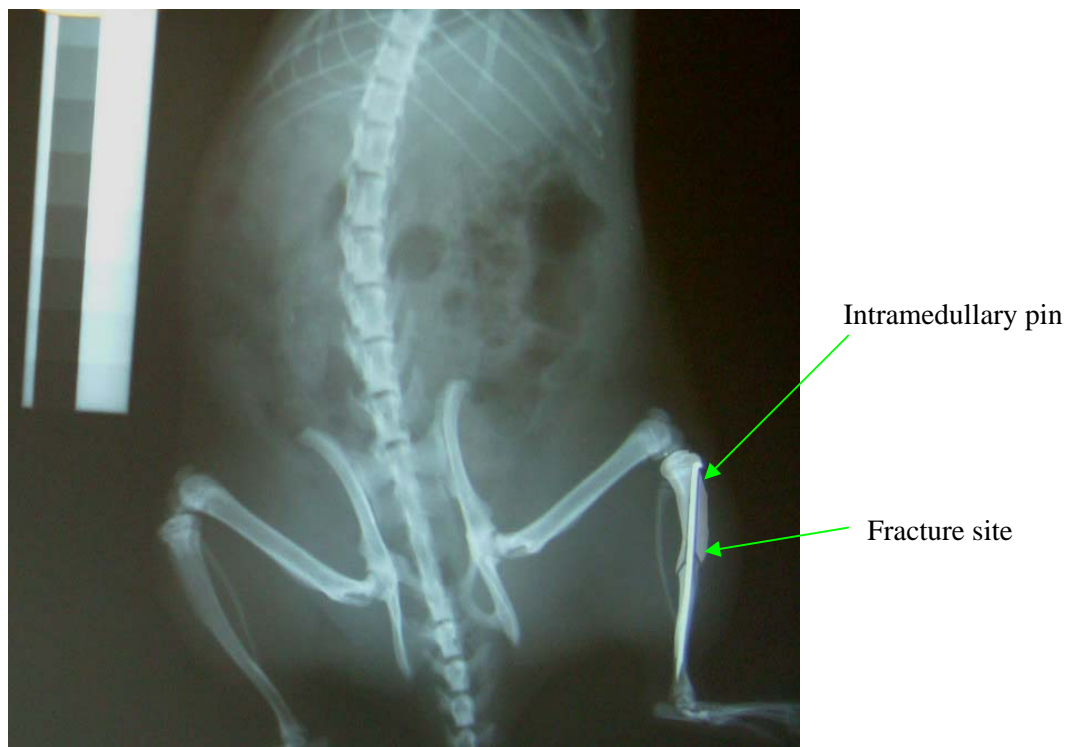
Lateral tibial radiograph for evaluating the position and orientation of the fracture.
